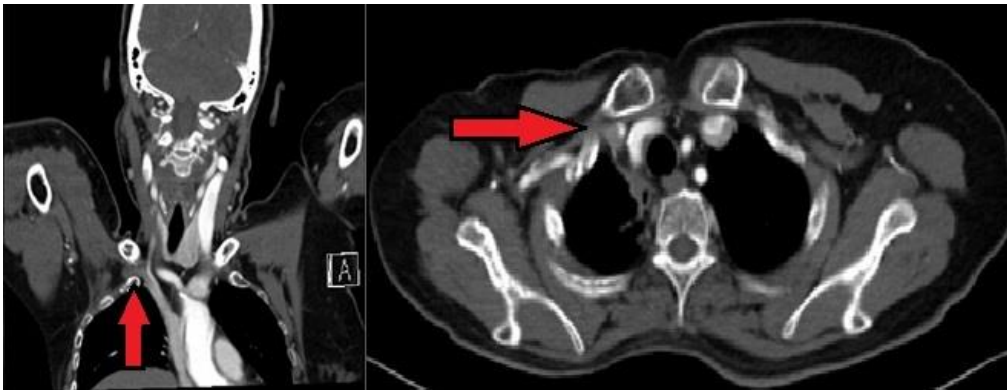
Computed tomography showed focal right subclavian vein stenosis at costoclavicular junction.
